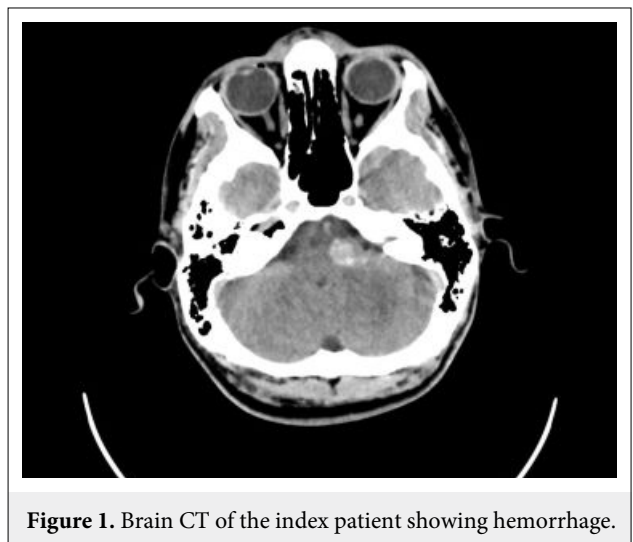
Brain CT of the index patient showing hemorrhage.
